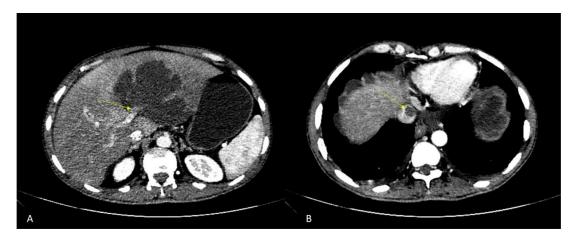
Case 3: Contrast-enhanced CT axial showing (A) compression of the left portal vein by the lesion (yellow arrow); (B) an eccentric hypodense filling defect in the suprahepatic IVC (yellow arrow).
